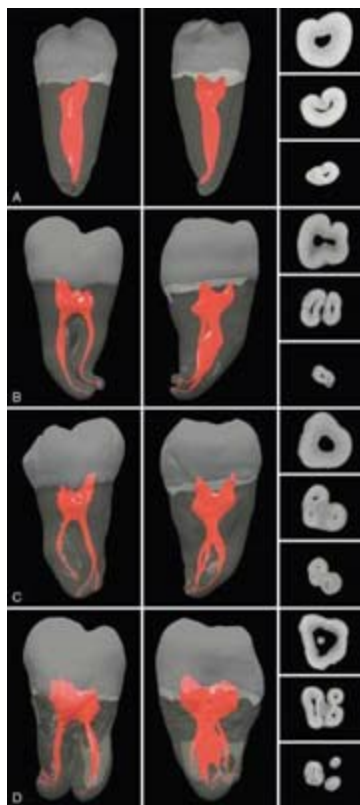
μ CT scans of mandibular third molars represent multiple variations for this tooth. A, Single C-shaped type canal. B, Complex anatomy with significant canal curvatures apically. C, Three canals that curve in multiple directions. D, Flattened, ribbon-shaped canals with significant apical curvatures. All teeth are shown from both a buccal (vestibular) and a proximal perspective, along with the cross-sectional anatomy at the coronal, middle, and apical levels. (See Video 7.19 online at the Expert Consult site for rotational views of these teeth.)
